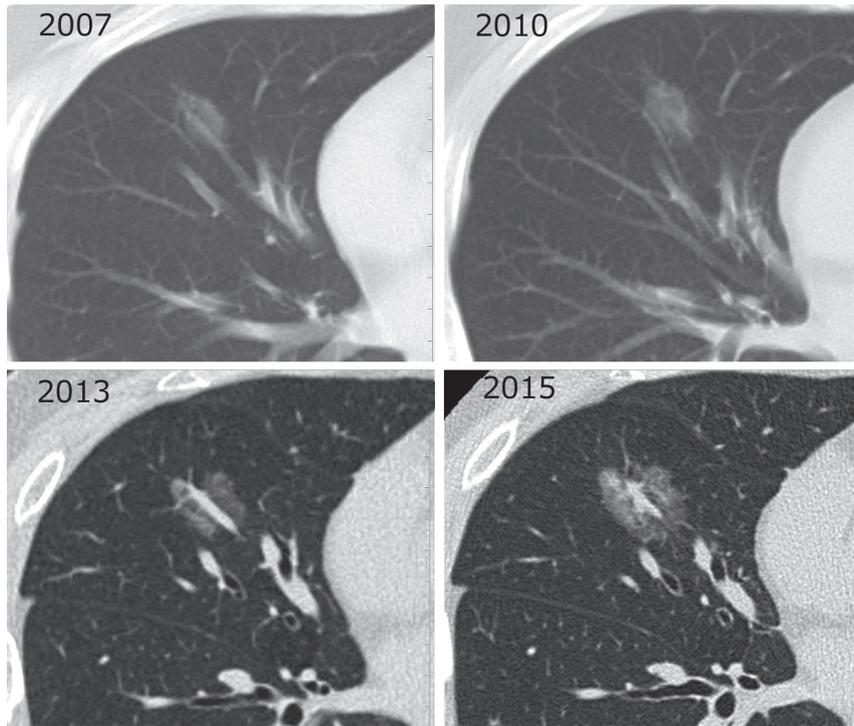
Annual Changes in CT Findings in Case 1
